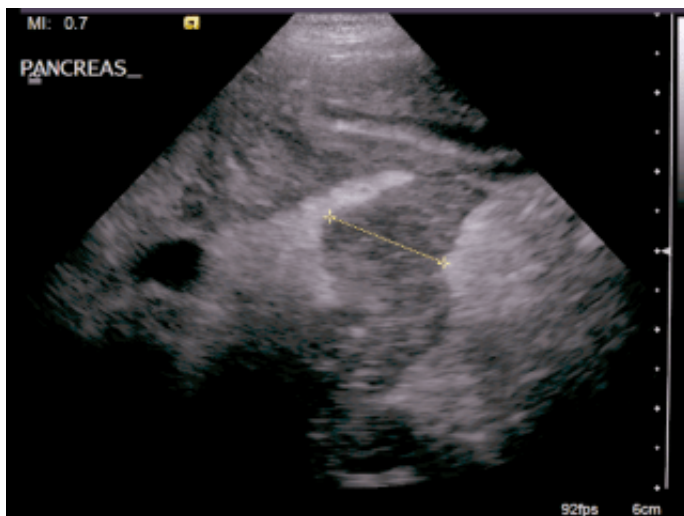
Ultrasonographic appearance of acute pancreatitis in a four-year-old male neutered bichon frise, with enlarged hypoechoic pancreas and surrounding hyperechoic mesenteric fat.
